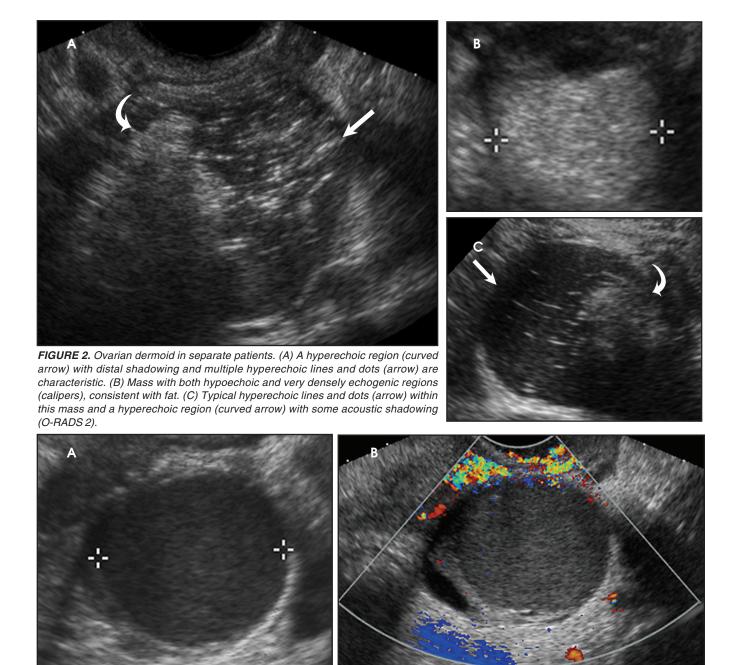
Endometrioma. (A) Initial ultrasound examination demonstrating adnexal mass (calipers) with homogeneous, ground-glass, lowlevel echoes. (B) Three-month follow-up ultrasound exam demonstrates similar findings with no color flow within the mass, confirming the diagnosis (O-RADS 2).
